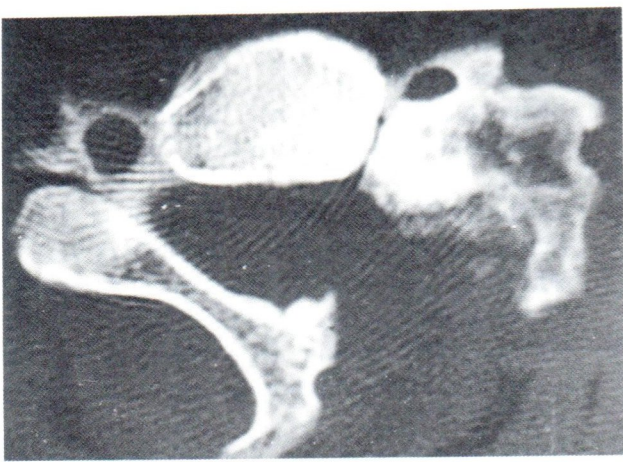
Incomplete removal of the mass was obvious at the follow up CT scan.
